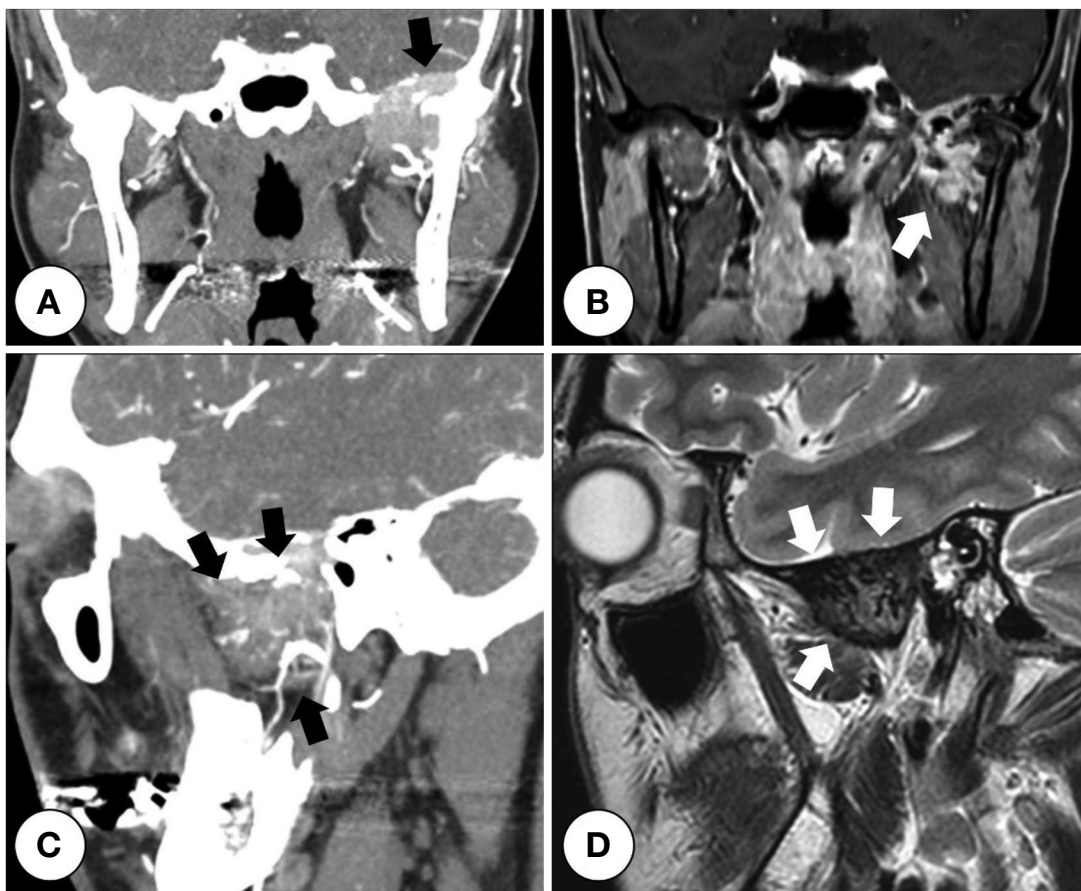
Imaging features of central giant cell granuloma (Case 1). A. Coronal view of contrast-enhanced computed tomography (CT) image presents a well-encapsulated, lobulated enhancing mass with bony destruction of condylar head and temporal bone (black arrow). B. On gadolinium-enhanced T1-weighted magnetic resonance image (MRI), lesion reveals enhancement with internal dark foci on medial side of the mandibular condyle (white arrow). C. Sagittal view of contrast-enhanced CT presents the mass described above at the anterior and inferior of the articular eminence (black arrow). D. Sagittal view of T2 weighted MR image shows slightly high signal intensity surrounded by dark signaled rimming suggesting the hemosiderin deposit (white arrow).
